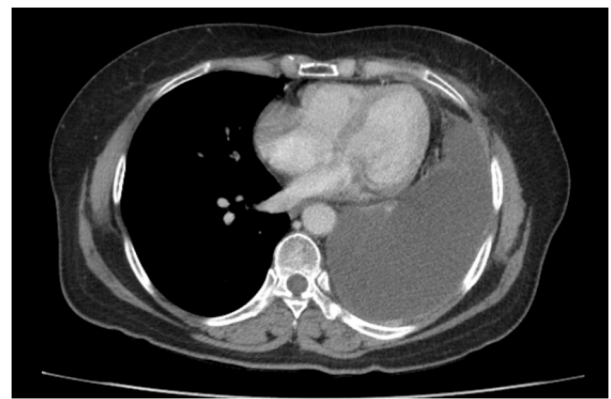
Chest CT scan 3 months after epidermal growth factor receptor-tyrosine kinase inhibitor therapy. A large amount of left pleural effusion was noted.
